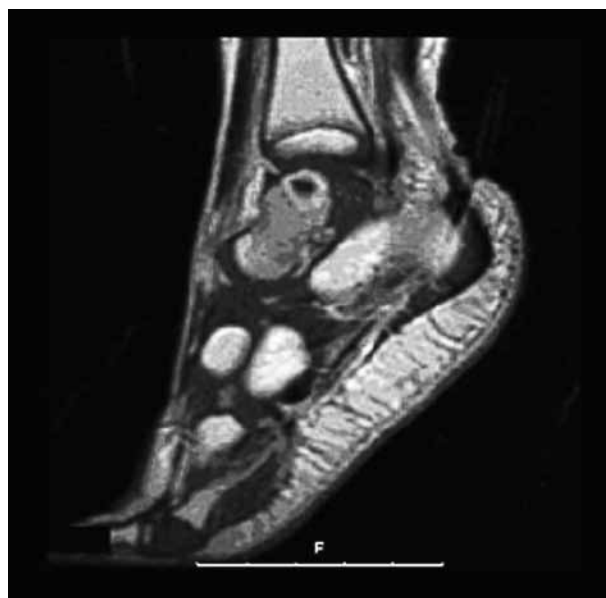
Penumbra sign of primary subacute osteomyelitis on T1-weighted sagittal MRI images of case 1 (patient LW) at diagnosis.
